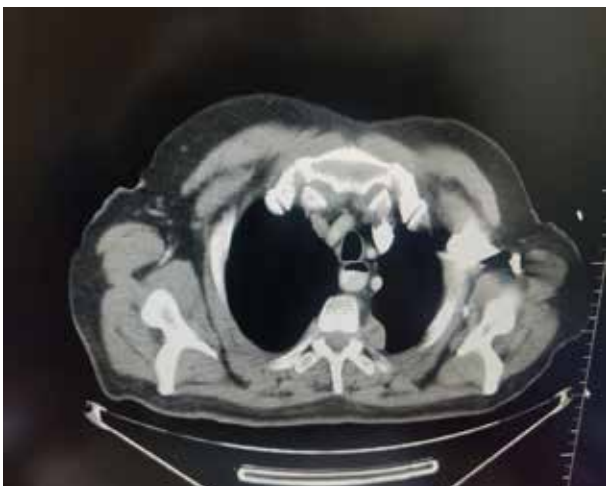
a, b: Left apical pleural and subpleural nodular metastatic lesions, seen on contrast enhanced axial CT scan.
